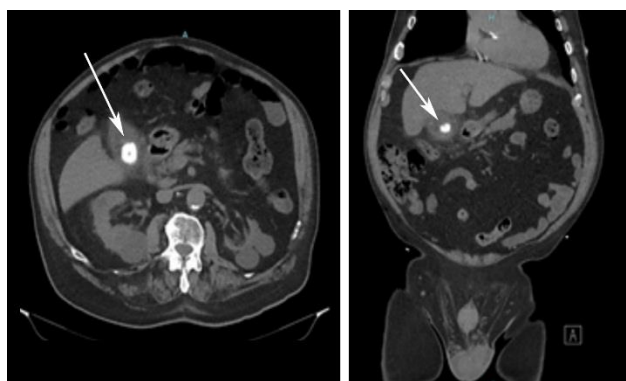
Axial and coronal views of the pre-operative CT scan, demonstrating a 2.3 cm gallstone (arrow) and changes consistent with cholecystitis including gallbladder wall thickening and pericholecystic fat stranding.
